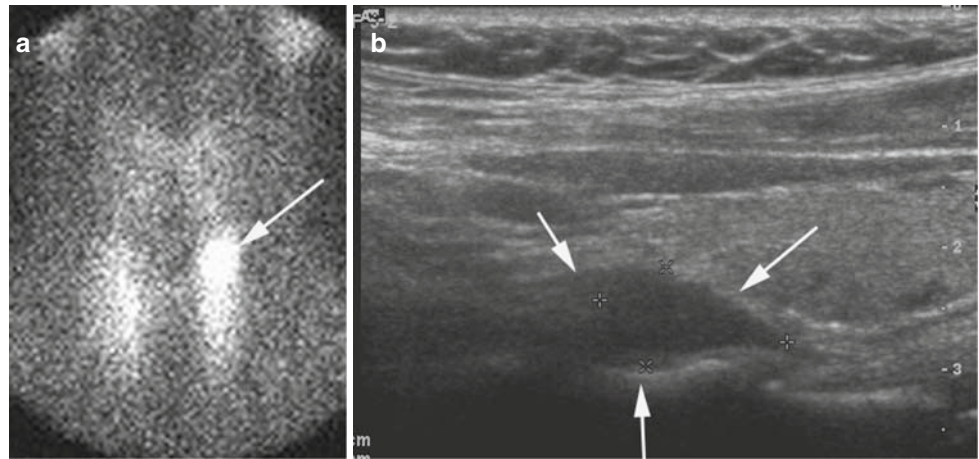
Parathyroid adenoma imaging. Technetium-99m sestamibi scan (a) on a 32-year-old woman with hyperparathyroidism demonstrates a focus of increased uptake overlying the upper pole of the thyroid (arrows), which corresponded to a hypoechoic lesion in this locale (arrows) on the corresponding ultrasound examination (b). This was a surgically proven parathyroid adenoma
